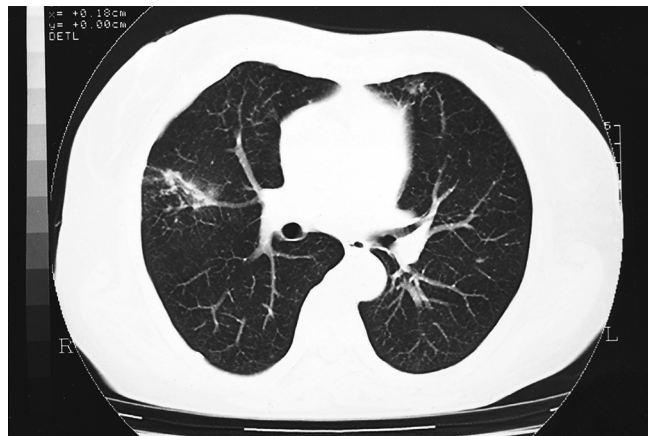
CT shows small nodular shadows in middle of right lung fields. Small granular shadows developed in bilateral lung fields. Pleural thickness and calcification were also detected
